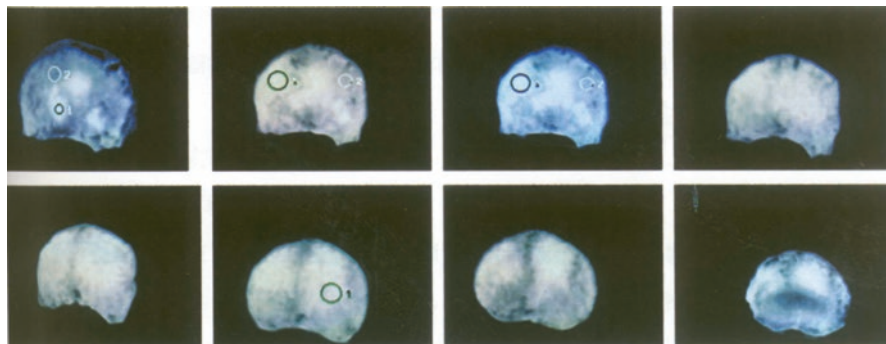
CT images of ICPC filling areas (Which is reproduced from Ref. [78] by permission)
